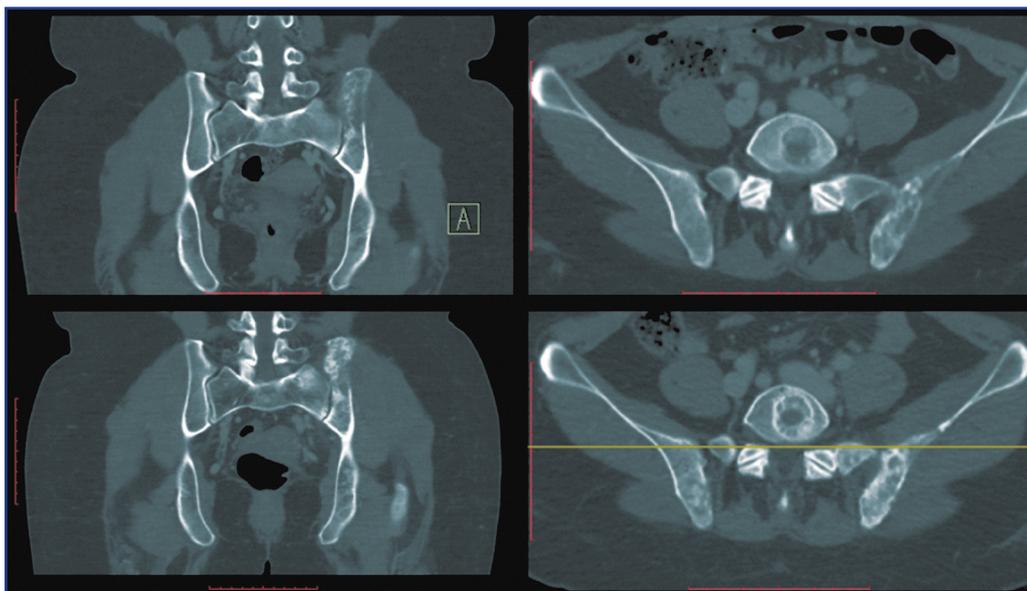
CT of the skeleton bones from July 2018 in comparison with March 2018. There is a stabilization of the process with positive dynamics in the form of osteosclerosis sites
